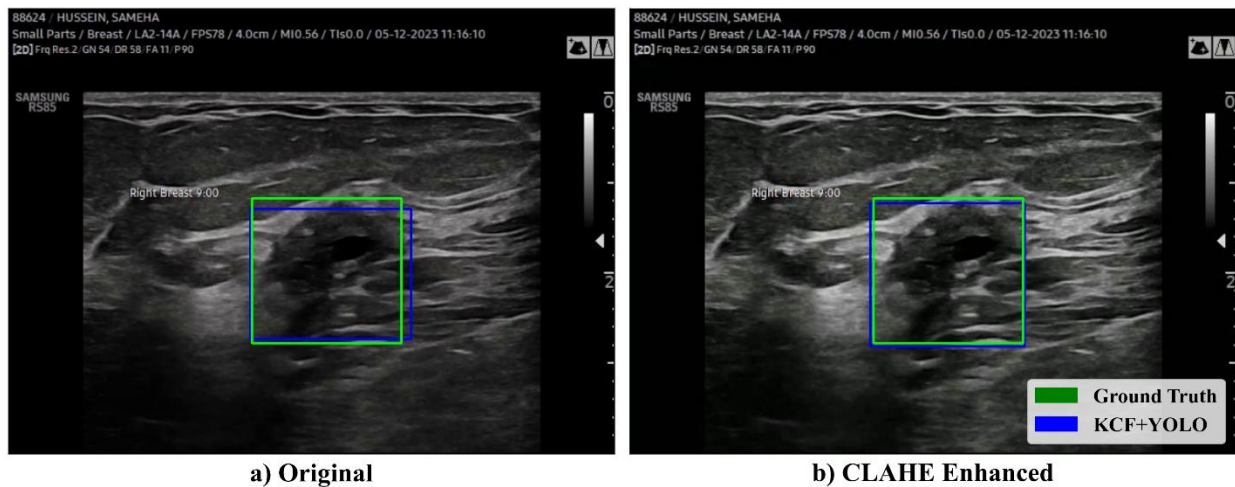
Qualitative Comparison of KCF+YOLO Tracking Results on Original and CLAHE-Enhanced Ultrasound Frames
